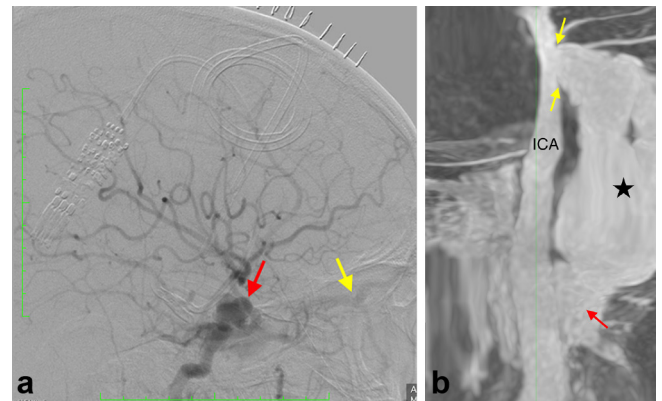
Angiographic and post processed reconstructed CBCT image, showing (a) right ICA angiographic run (lateral view) showing the aneurysmal vessel (red arrow) and the dilated SOV (yellow arrow). (b) Post processed reconstructed CBCT image showing the neck of the pseudoaneurysm (yellow arrows), in continuation with the pseudoaneurysm (star) and cavernous sinus (red arrow). The ICA is labelled. CBCT, cone beam CT; ICA, internal carotid artery; SOV, superior ophthalmic vein.
